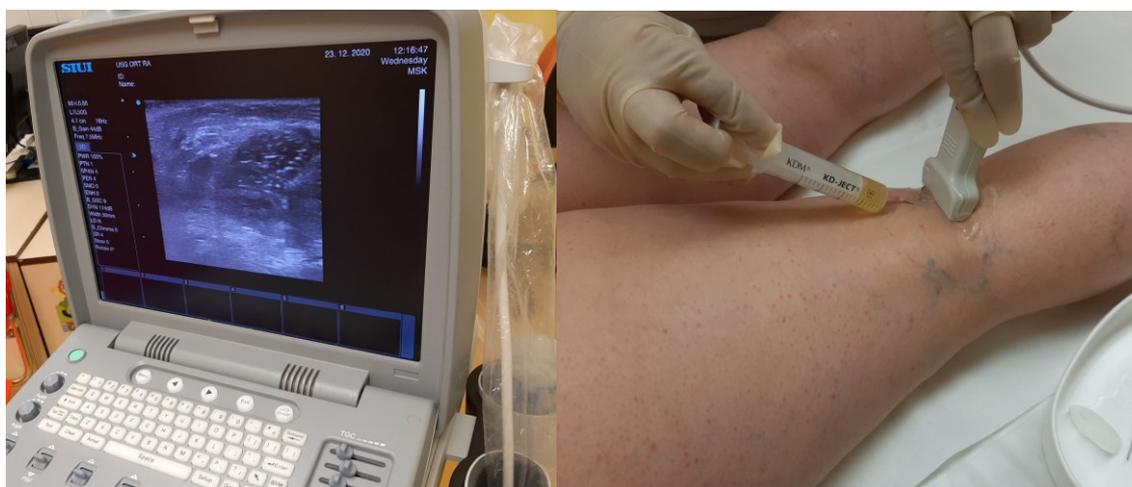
56 Ultrasound-Guided Aspiration of a Baker's Cyst
